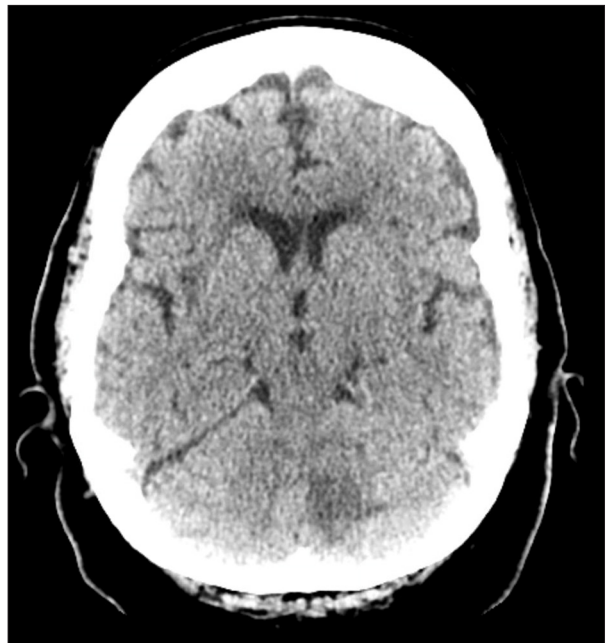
Computed tomography of the head, showing hypoattenuation in the left cerebellum, predominantly involving the white matter, with mass effect on the fourth ventricle and appearance of vasogenic edema.
